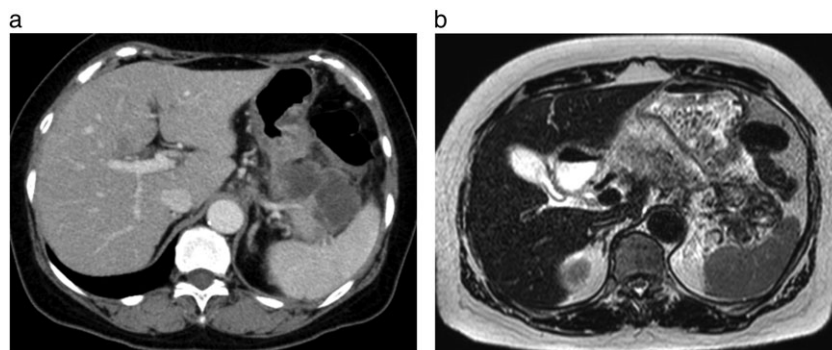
Detection of solid components in a cavity of walled-off necrosis (WON). (1a) Contrast-enhanced computed tomography did not reveal solid components in WON cavities. (1b) Magnetic resonance imaging showed solid components in WON cavities.
